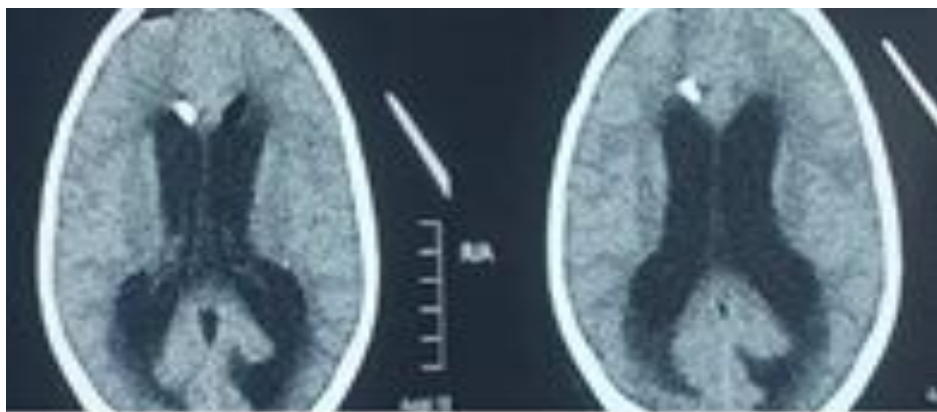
Brain CT scan showing acute tetraventricular hydrocephalus.
